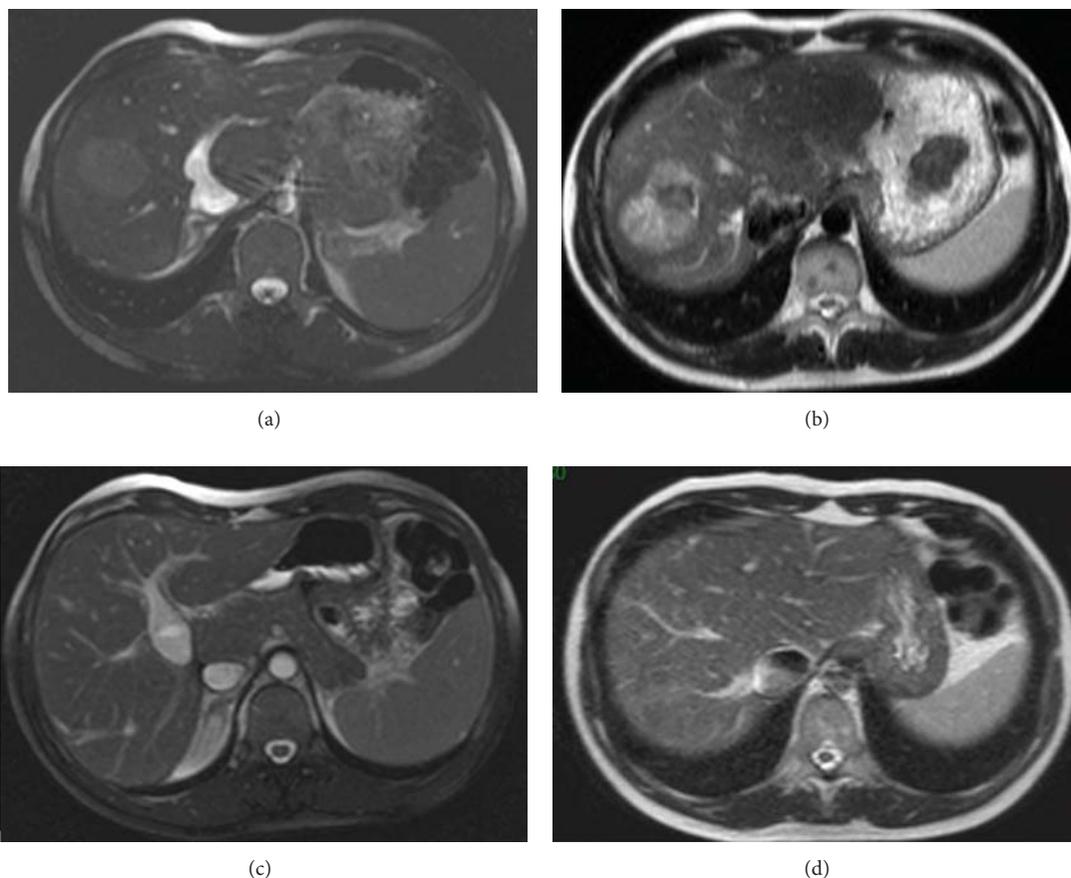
Adenoma associated with CPSS. Aspect on MRI at diagnosis and 10 months after surgical closure of the shunt: (a) T2 WI-balanced sequence shows the CPSS consisting of a patent ductus venosus. Note that the tumor is not easily visible in this sequence. (b) The 4 cm diameter HCA lies in segment 8, and it is better seen on T2 WI and appears heterogeneous and mainly hyperintense compared to the surrounding liver. MRI performed 10 months after surgical closure of the shunt (c) shows the complete disappearance of the tumor (d).
